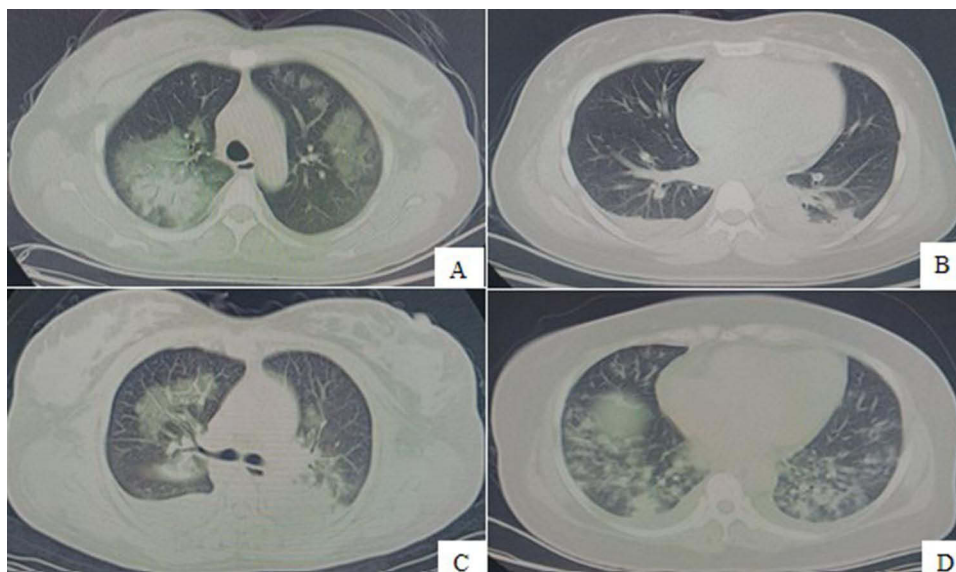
A 28-year-old parturient with a bigeminal pregnancy and severe hypertension during pregnancy experienced significant shortness of breath. After delivery, her oxygen saturation (SpO₂) was 89% without supplemental oxygen, and chest computed tomography (CT) revealed pulmonary edema (A); A 32-year-old parturient was asymptomatic, with an SpO₂ of 92% without supplemental oxygen after delivery. Chest CT showed mild atelectasis in both lower lungs with minimal pleural effusion (B); A 30-year-old parturient reported chest tightness and shortness of breath. Her SpO₂ was 90% without supplemental oxygen after delivery, and chest CT revealed concurrent partial atelectasis, pleural effusion, and pulmonary edema (C); Another 30-year-old parturient developed postpartum fever and cough, with an SpO₂ of 91% without supplemental oxygen. Chest CT indicated pneumonia (D).
